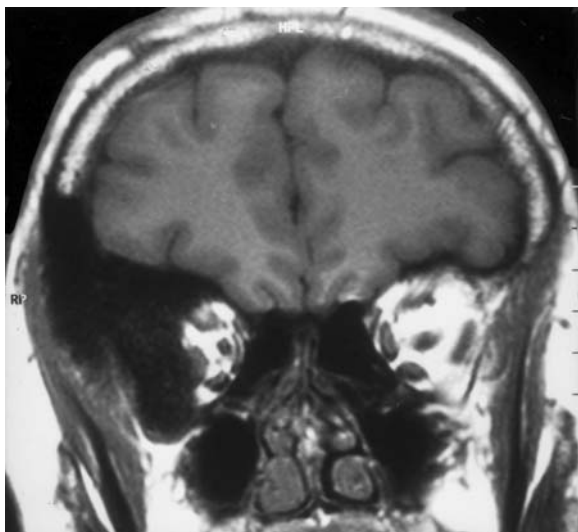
A 50-year-old woman with slowly progressing protrusion of the right eye persisting for the past 3 years, and concomitant nonlocalized headache, but without neurological symptoms. Diagnosis: meningioma of the right sphenoid wing. CT: a Axial HR image in bone window at the level of the optic canal. Compared with the left side, the lateral sphenoid wing, the zygomatic bone, and the rostral part of the temporal bone are characterized by irregular sclerosing of the entire bone, including the tabula interna, external, and diploë with exostotic growth into the temporal fossa. b Coronal HR-CT with irregular, knotty sclerosis and thickening of the right sphenoid, also invading the frontal and zygomatic bone. c Oblique coronal view of a 3D-CT reconstruction. MR: d Axial T1-weighted native view (corresponding to a). Note thickening of the temporo-polar dura (small arrows). e After i.v. gadolinium, not only the invaded temporo-polar dura shows signal enhancement, but some dotted, hazy signals are also seen in parts of the thickened bone. f Coronal T1-weighted native image (corresponding to b) with superior visualization of the space-occupying effect with compression of the posterior part of the upper orbit, compared to the left side
